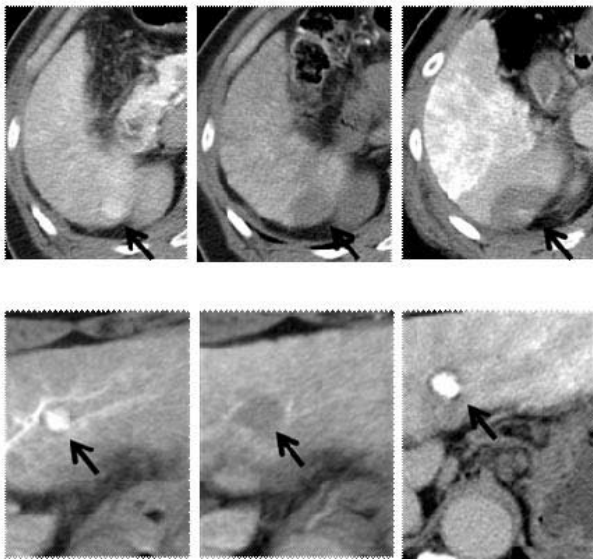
The upper is the image of hepatocellular carcinoma at the time of first treatment in December, 2007. (Upper left) CTHA, contrast material injected; (Upper middle) CTAP, defect region is found in hepatocellular carcinoma about 2.3 cm in size located at segment 6; (Upper right, dynamic CT) the patient underwent radiofrequency ablation and achieved complete ablation. The lower is the image of recurrence hepatocellular carcinoma at the time of second treatment in November, 2009. (Lower left) CTHA, contrast material injected; (Lower middle) CTAP, defect region is found in hepatocellular carcinoma about 1.5 cm in size located at segment 2; (Lower right, dynamic CT) the patient underwent radiofrequency ablation and achieved complete ablation.
